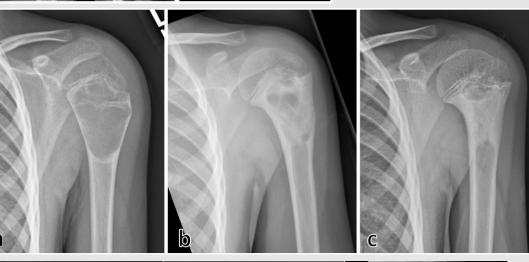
Humeral radiographs of UBC a. 4 weeks after initial presentation (healed fracture line evident) b. 1.5 months after the first injection c. 9 months after the second injection
